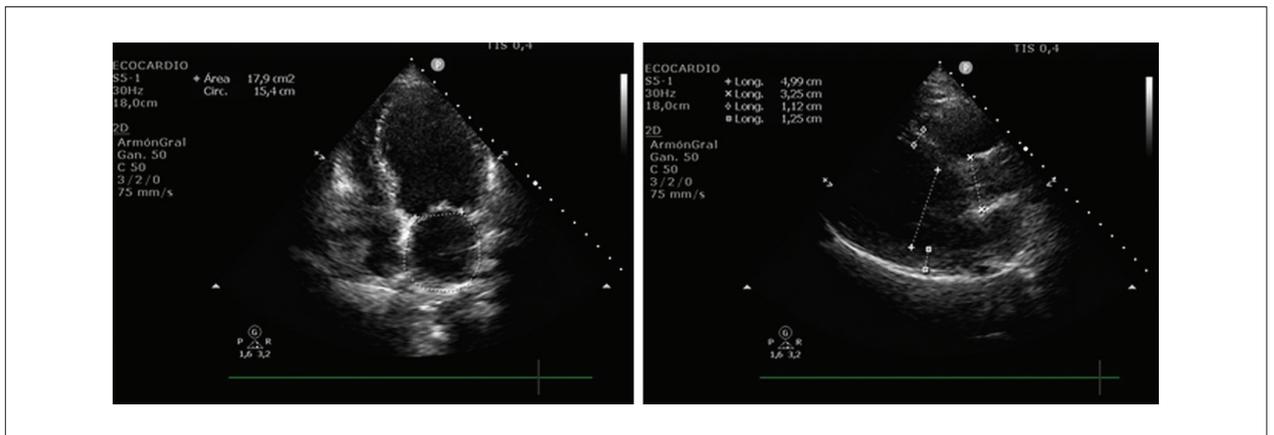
Transthoracic echocardiogram showing diffuse hypokinesia of the left ventricle and a left ventricular ejection fraction (LVEF) of 28%.
